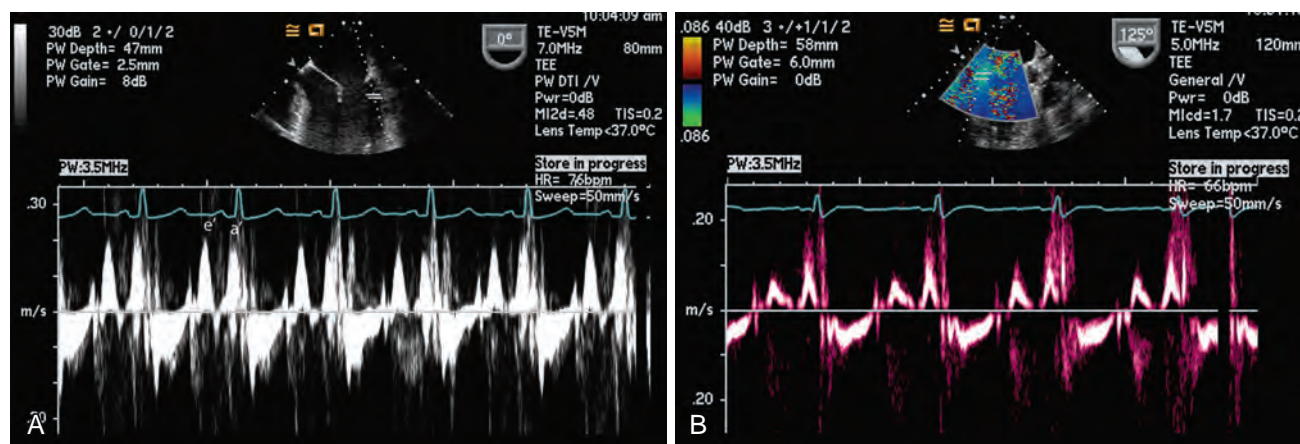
Tissue Doppler measurements. (A) Normal tissue Doppler spectrum. e' is both greater than a' and more than 8 cm/sec. (B) With worsening left ventricular diastolic function, the e' velocity decreases.
